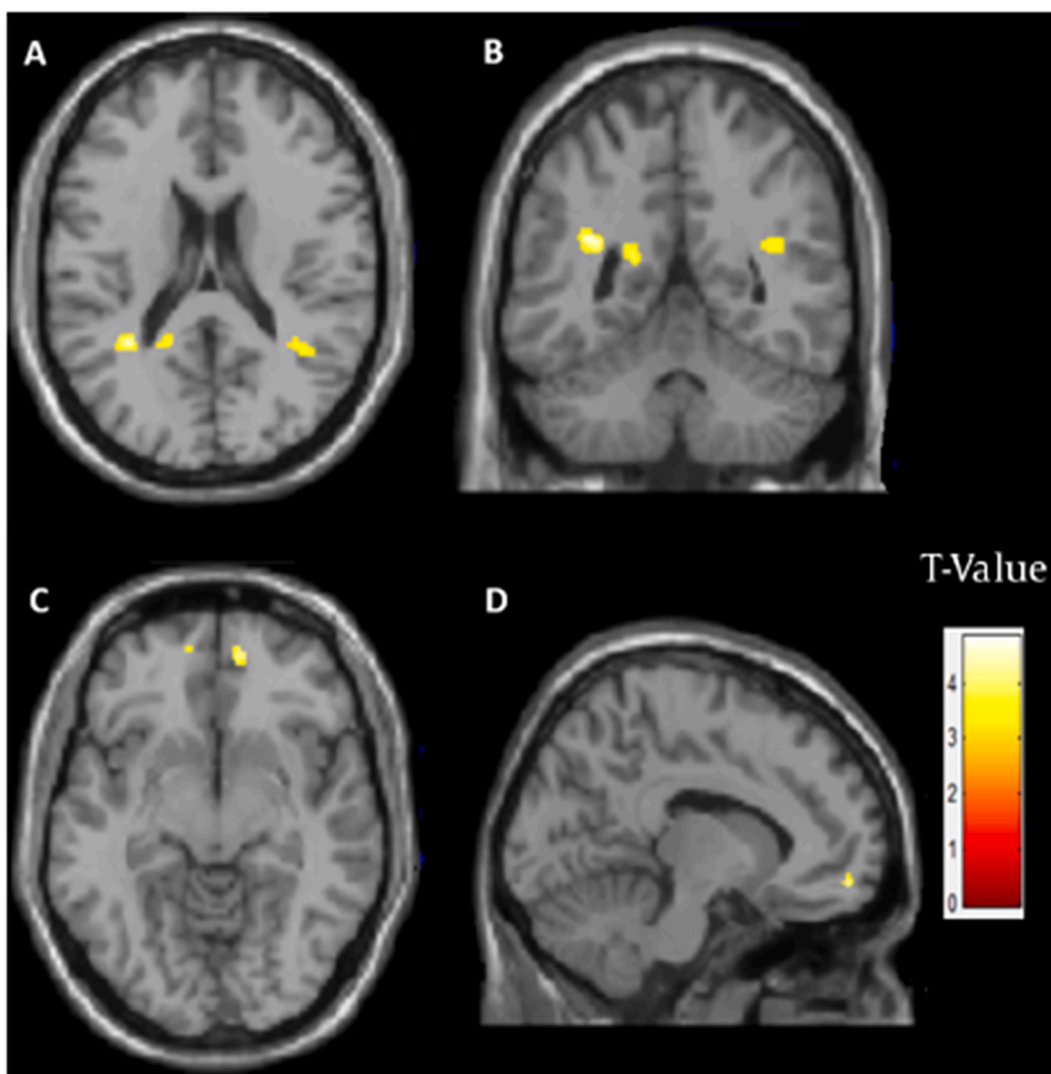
Comparison of the structural MRI in MA abusers and control subjects using VBM and independent two-tailed t-test analysis. A, B. Transverse and coronal view of the brain, increased white matter volume in the right superior temporal gyrus (RSTG) and left temporal lobe (LTL) in MA-dependent patients relative to controls. C, D. Transverse and sagittal view of the brain, increased white matter volume in right frontal lobe sub-gyral and Left medial frontal gyrus in MA-dependent patients relative to the controls (P-value < 0.001 FWE < 0.05).
